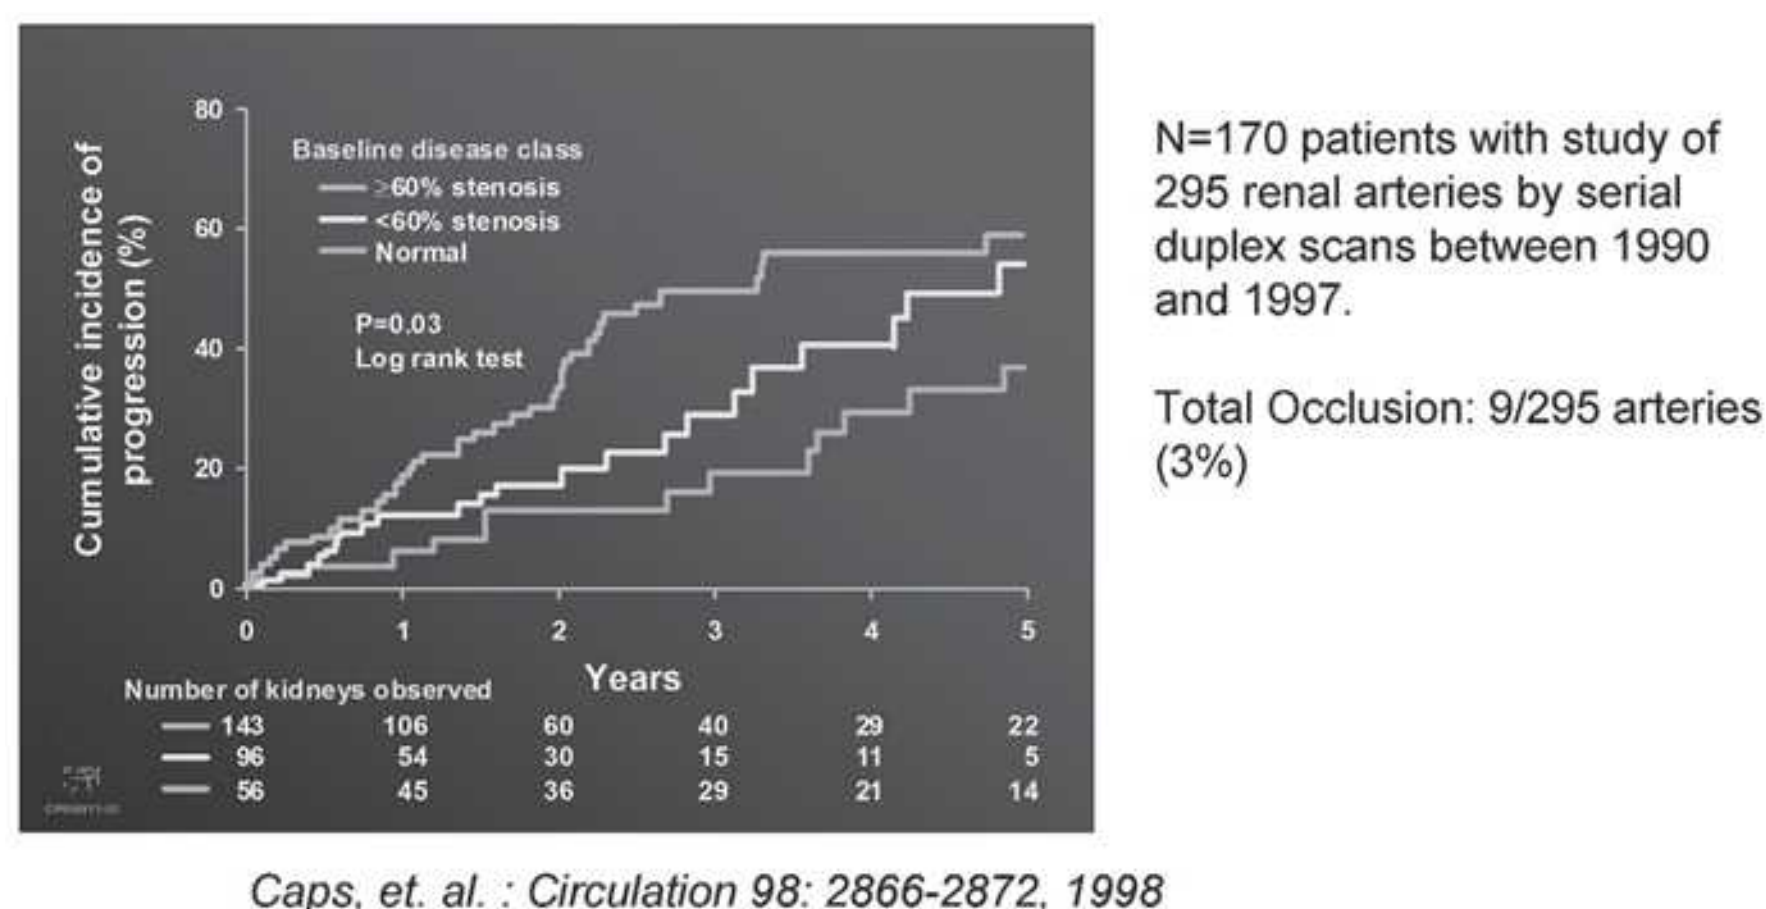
The progression of atherosclerotic renal artery stenosis (ARAS) of varying severity during a serial follow-up by Doppler ultrasound. There were 295 arteries that were followed sequentially at 6-month intervals for 5 years. Measurable hemodynamic progression (defined as an increase in peak systolic velocity of at least 100 cm per second) was identified in 31% by 3 years, and more than 50% of the group with more than 60% at baseline. Importantly, clinical progression was uncommon (defined by a change in serum creatinine, loss of kidney size, or total occlusion). Predictors of progression included systolic blood pressure, age, and diabetes. (Adapted from Caps MT, Perissinotto C, Zierler RE, et al. Prospective study of atherosclerotic disease progression in the renal artery. *Circulation*. 1998;98:2866–2872.) (See Color Plate.)
